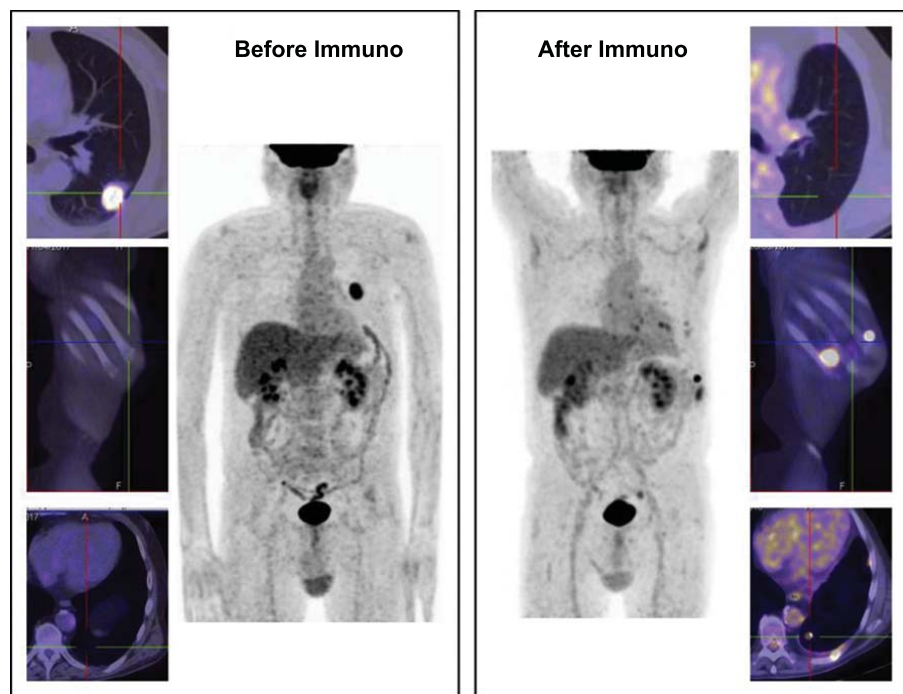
shows an example of FDG PET/CT before and after immunotherapy.
